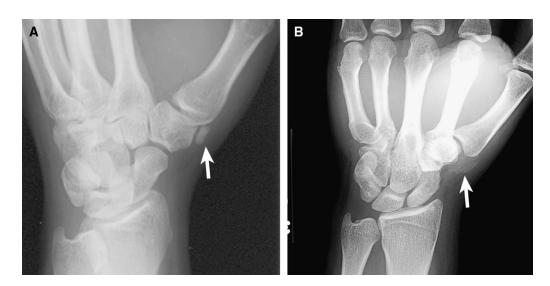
A 31-year-old man with right wrist pain after trauma. (A) Initial right wrist radiograph demonstrates a well-defined calcific density in the expected region of the abductor pollicis brevis tendon (arrow). The patient was not tender at this location. (B) Radiograph performed 3 months later shows a change in the appearance of the calcification from well defined to a hazy, amorphous density (arrow). The patient was symptomatic at this location, which indicates the resorptive phase of calcific tendinitis.
